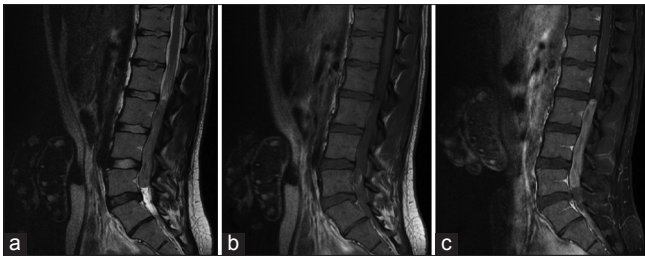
Magnetic resonance imaging L spine. Sagittal slices demonstrates lesion on T2 (a), T1 (b), and T1 with contrast (c)
